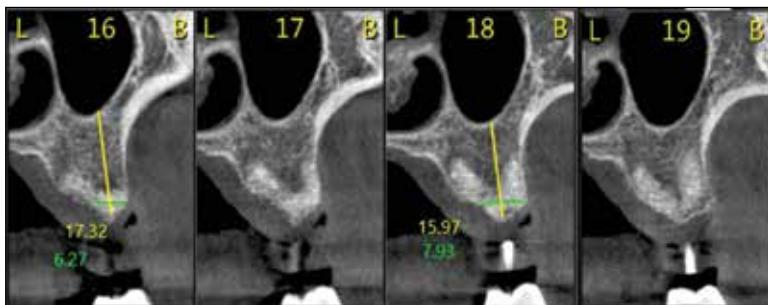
CT scan section cuts revealed that the particulate dentin preserved the entire socket site volume.
